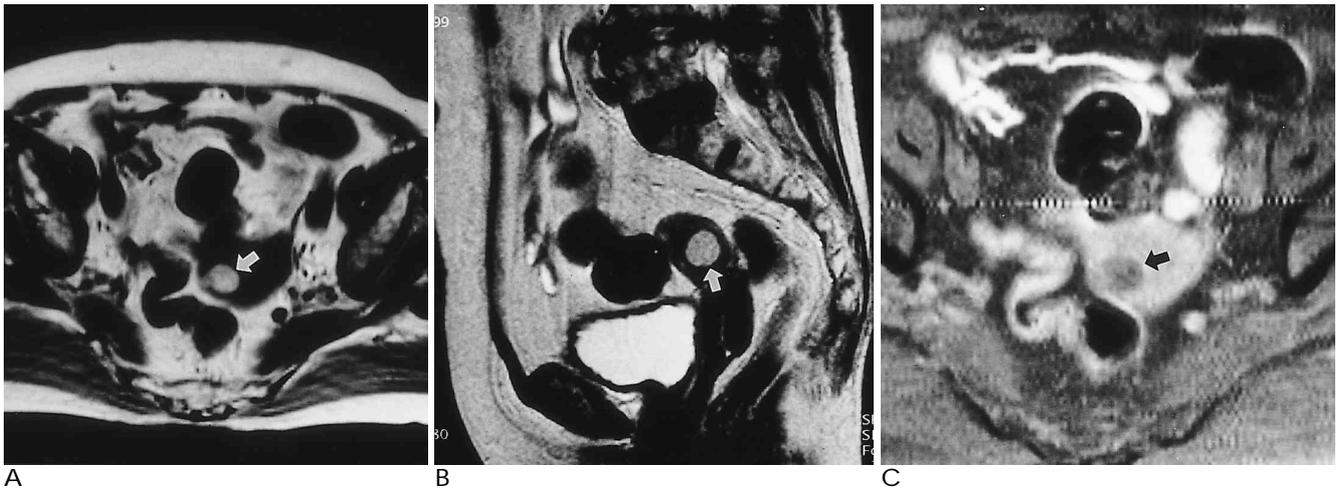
MR images of the pelvis in a 72-year-old woman
